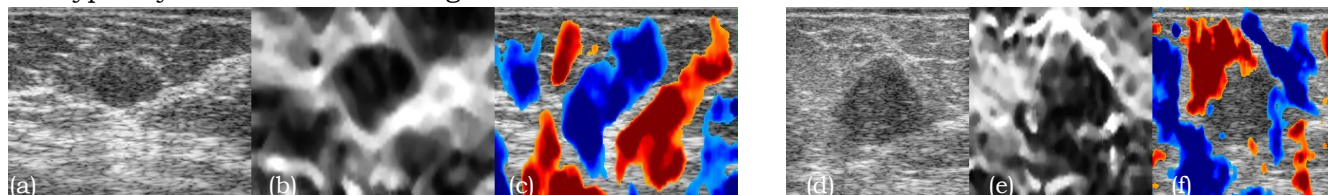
An example frame of (a, d) Sonogram, (b, e) ASE and (c, f) ASSE from a cine-loop of freehand compressed *in vivo* breast lesion data. The data were pathologically confirmed as benign fibroadenoma (a, b, c) (30mm x 38mm); malignant invasive ductal carcinoma (d, e, f) (40mm x 38mm). Observe the presence in the ASSE image of significant non–zero axial–shear strain inside the fibroadenoma (c) only (referred to as “fill–in”), along with high contrast margins of opposite polarity. This characteristic appearance is conspicuously absent in the case of cancer (f).
